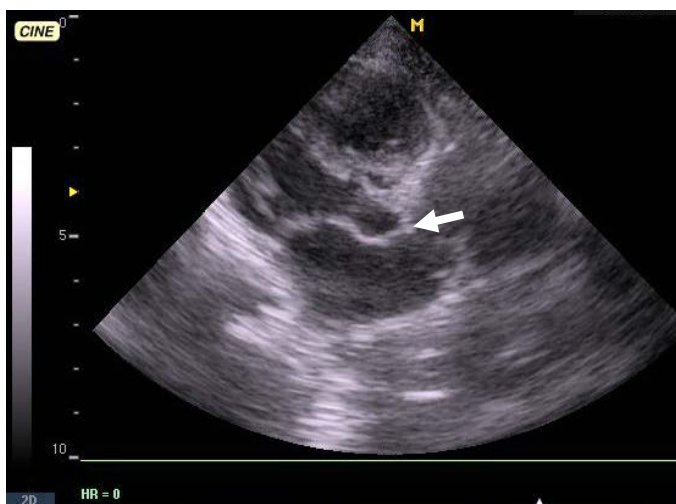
Two-dimensional echocardiography (research from apex position). Aortic stenosis: fibrosis and thickening of leaflets of aortic valve (arrow)
